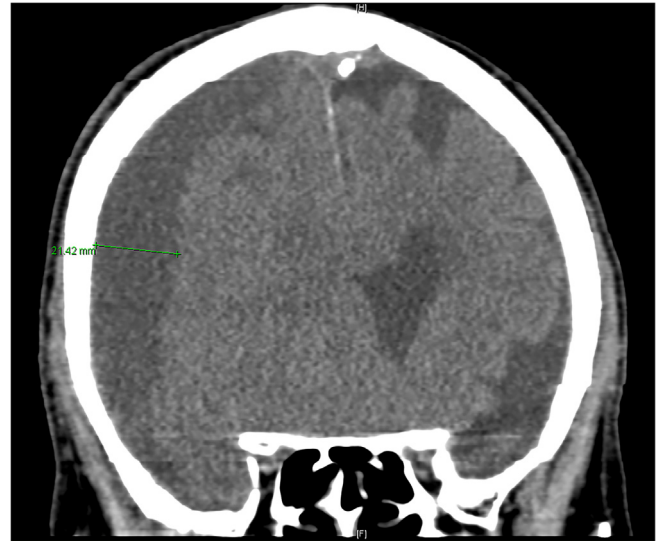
Coronal non-contrast computed tomography showing chronic subdural hematoma with width of 21.42 mm.
